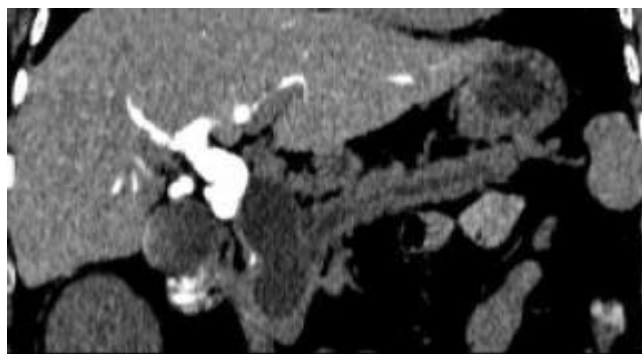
Real cyst of pancreas. Curved planar reformations obtained after CT cholangiography showed the dilatation and obstruction of bile duct system, and the beaded-like dilatation of pancreatic duct. The cyst located beside the common bile duct. There was no contrast media entrancing into cyst.
